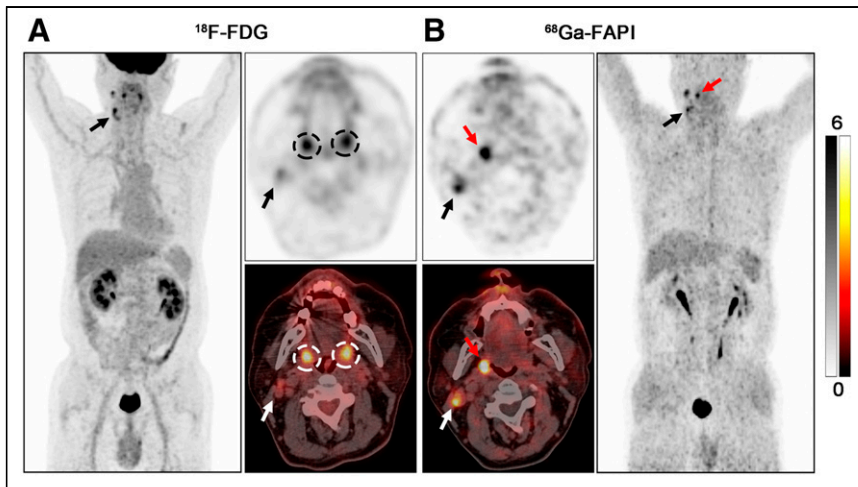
PET/CT scans with ^{18}F -FDG (A) and ^{68}Ga -FAPI (B) in 63-y-old male patient (patient 2) with metastatic SCC of right neck. ^{18}F -FDG PET/CT was negative for detection of primary. Increased uptake of ^{18}F -FDG was detected in palatine tonsils of both right and left sides (A, black and white dashed circles; $\text{SUV}_{\text{max}} = 6.40$ and 6.00 , respectively), resulting an SUV_{max} ratio of 1.07. On ^{68}Ga -FAPI PET/CT, there was asymmetric fullness with intensive uptake in right palatine tonsil (B, red arrow; $\text{SUV}_{\text{max}} = 8.30$), whereas low background uptake was seen in left palatine tonsil (SUV_{max} ratio = 3.46). Subsequent tonsillectomy confirmed SCC. Black and white arrows indicate metastatic lymph nodes.
